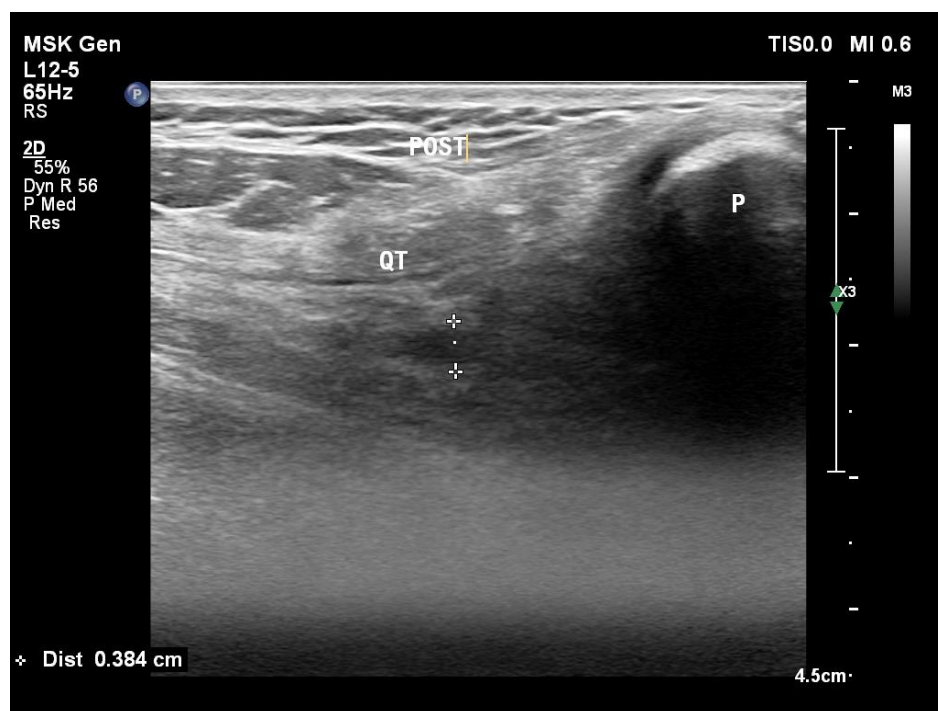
Post injection suprapatellar pouch anterior-posterior dimension measurement using ultrasound
